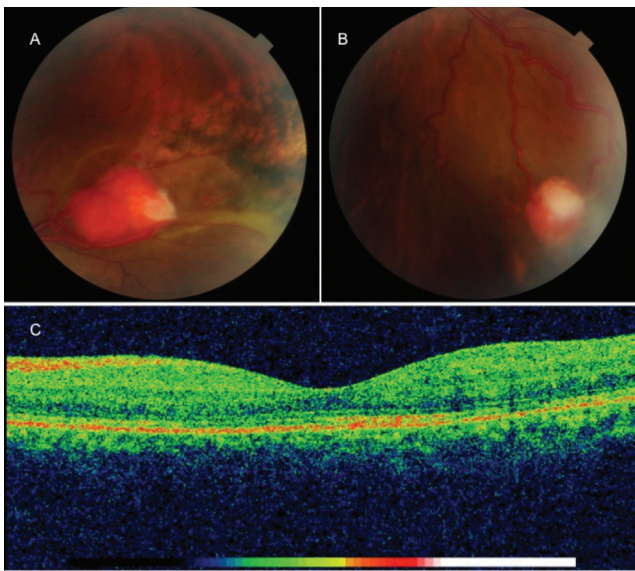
Images of the (A) superotemporal and (B) inferotemporal hemangioblastomas in the left eye after cryotherapy. (C) Ocular computed tomography image showing regression of the perifoveal intraretinal cystic fluid
